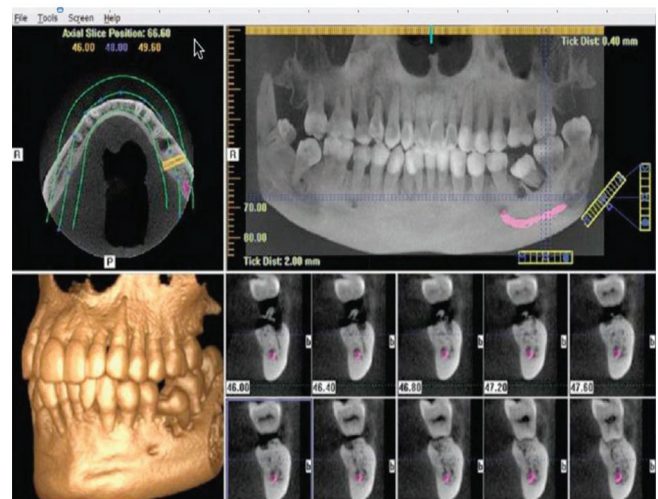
Shows various sections of cone beam computed tomography
